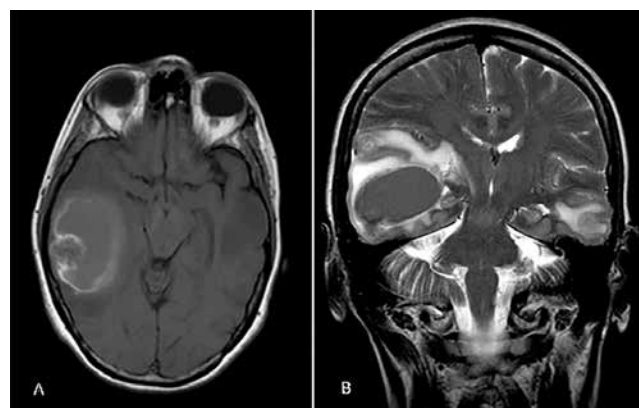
Brain MRI. (A) Axial T1-weighted image showing a cortico-subcortical tumoral lesion at temporal lobe with predominant moderate hyperintensity and an irregular halo of higher signal. The spontaneous high signal on T1 is probably due to both a hemorrhagic component and the melanocytic content. (B) Coronal T2-weighted image showing the lesion described in (A) and additional two smaller cortico-subcortical masses located at right posterior frontal lobe and at left inferior temporal gyrus. All the lesions had low signal on T2, particularly the inferior solid component of the major tumoral mass, which is also compatible with a melanocytic content. Another milimetric lesion was found at left precuneus (not shown). The hypointensity on T2-weighted image (B) may also be associated at lung or gastrointestinal adenocarcinoma metastasis, however with the (A) axial T1-weighted image the hyperintense signal is typical of melanoma melanocytic.
